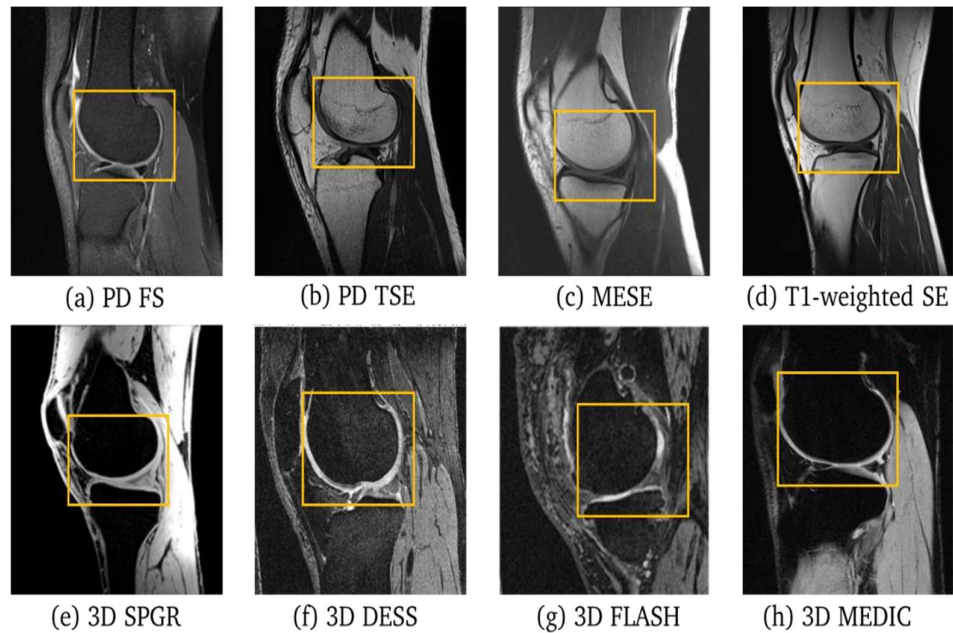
MR pulse sequences (a) PD fat suppression (b) PD turbine spin echo (c) multi echo spin echo (d) T1-weighted spin echo (e) 3D spoiled gradient echo (f) 3Ddual echo steady state (g) 3Ddissolute low angle shot (h) 3D multi echo data imaging combination
